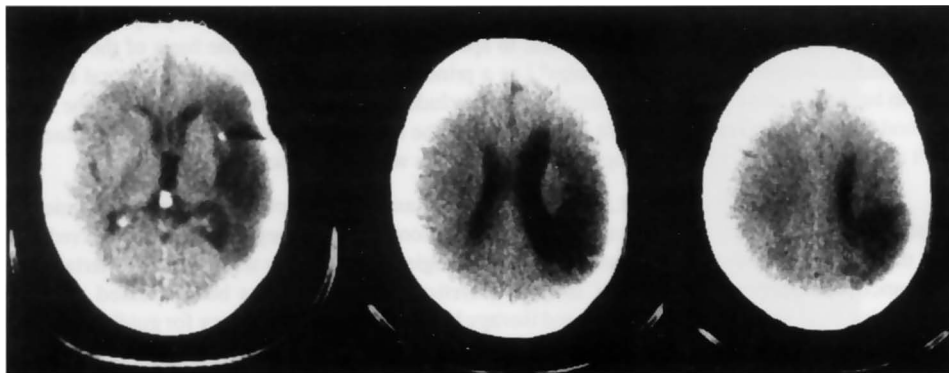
CT evaluation obtained four years after surgery. The CT image (10 mm transverse cuts) shows a well-defined and extensive area of low density in the left temporal, parietal and occipital lobes. Note the size of the left lateral ventricle, which is unequivocally enlarged, especially in the occipital horn (center cut).
